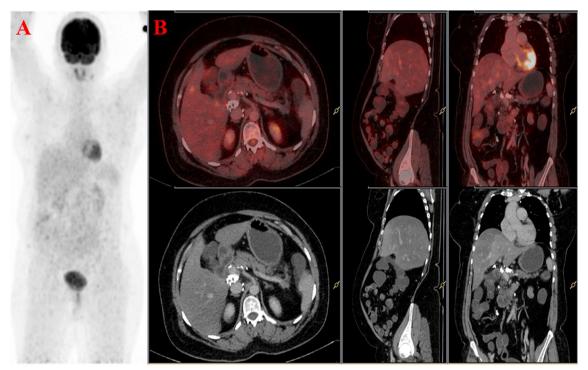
18F FDG PET/CT scan of a 55-year-old women was having right hypochondriac pain and pT1b stage and negative on PET/CT A, Maximum intensity projection image (MIP) B, PET/CT and corresponding CT at the gallbladder fossa region
